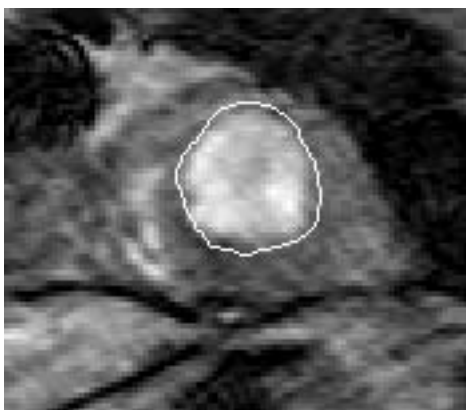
Example of MRI segmentation.
